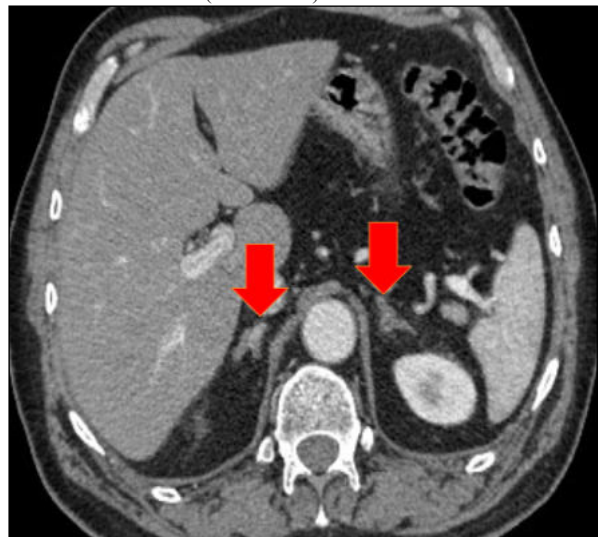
Bilateral Adrenal Hyperplasia Diagnosed Isenhanced CT
